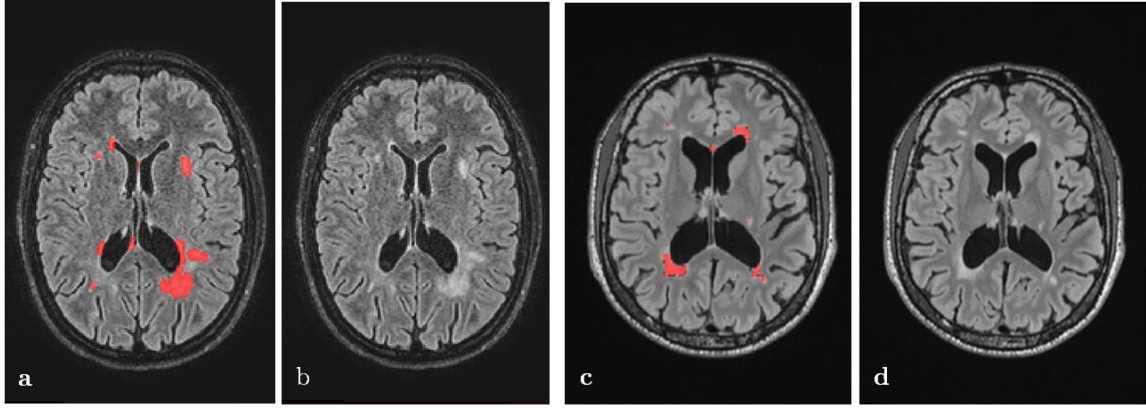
Examples of FLAIR images and lesion segmentation from two MS patients from two MS centers.
